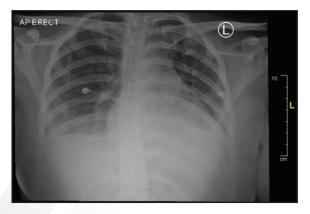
Chest x-ray showed slight cardiomegaly, congestion and pleural effusion
